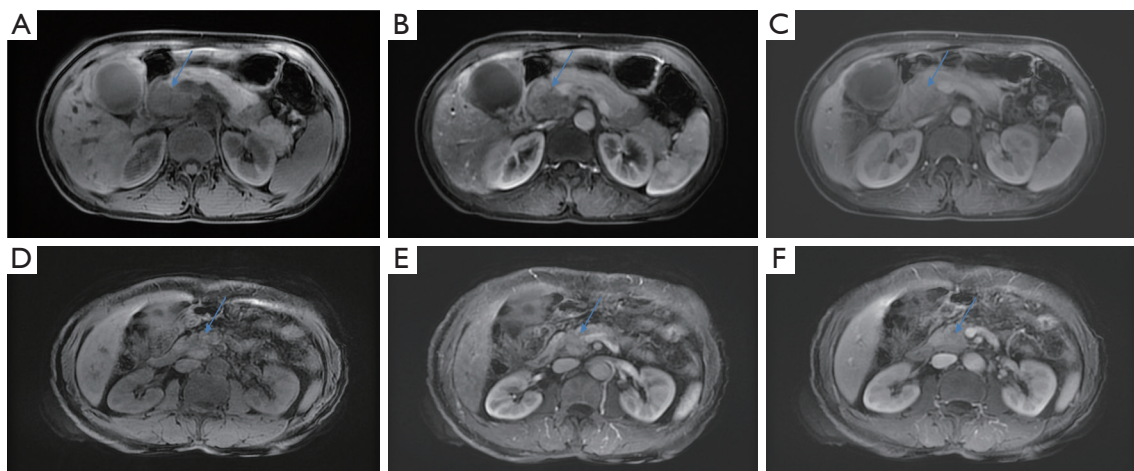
The preoperative MRI of MUC4 expression status of patients with PDAC. (A-C) MRI of high MUC4 expression; (D-F) MRI of low MUC4 expression. The multi-sequence MRI shows an irregularly shaped tumor with hypo-intensity on T1WI (A,D) and mild enhancement on the arterial phase (B,E) and the portal venous phase (C,F). All blue arrows point to the lesion. MRI, magnetic resonance imaging; MUC4, mucin 4; PDAC, pancreatic ductal adenocarcinoma; T1WI, T1-weighted imaging.
